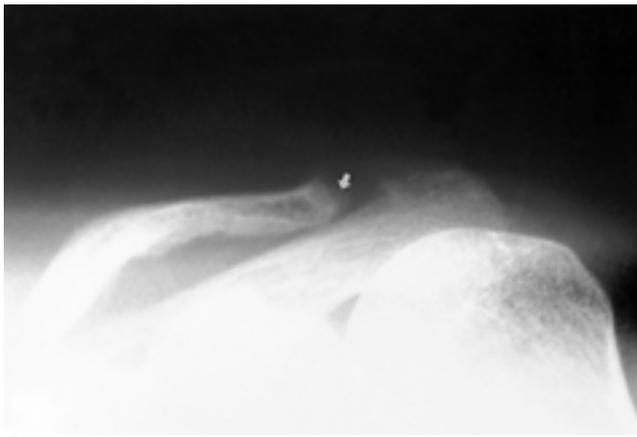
Plain radiographic findings representing secondary hyperparathyroidism
